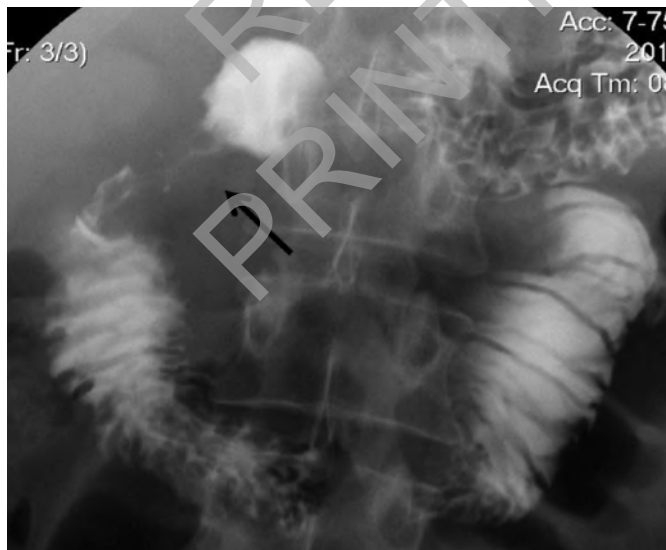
Case 1. Duodenal stenosis as evidenced by contrast x-ray film.
